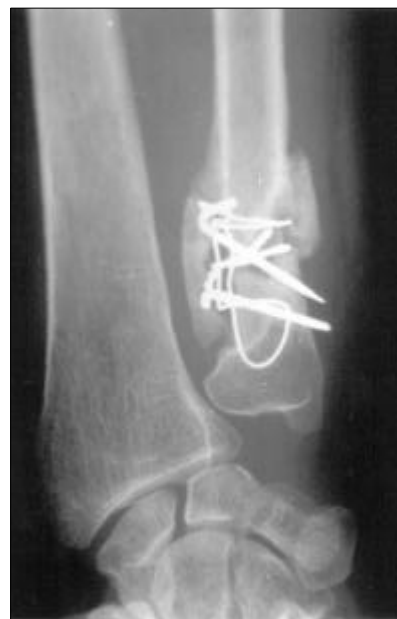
Hypertrophic delayed union noted at a postoperative 4 months X-ray of a type III isolated distal ulnar shaft fracture.
